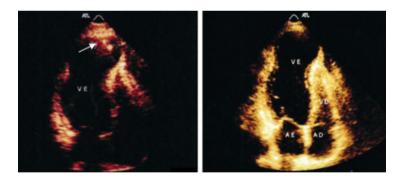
Two-dimensional echocardiogram showing left ventricular apical aneurysm with (*arrow*) and without thrombus
